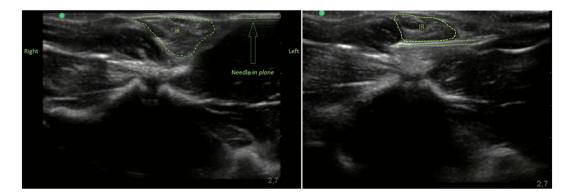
Ultrasound stills during in plane needling technique of UGIRS.
